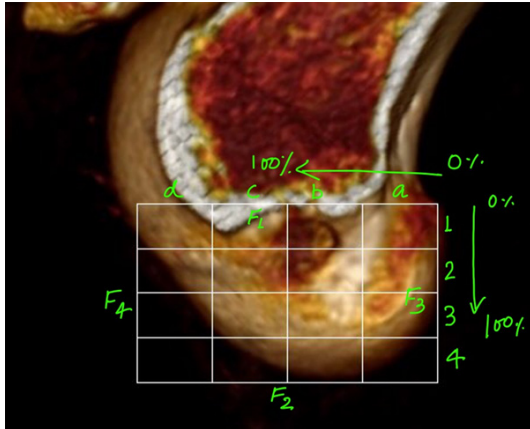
Three dimensional computed tomography of the lateral femoral condyle.
